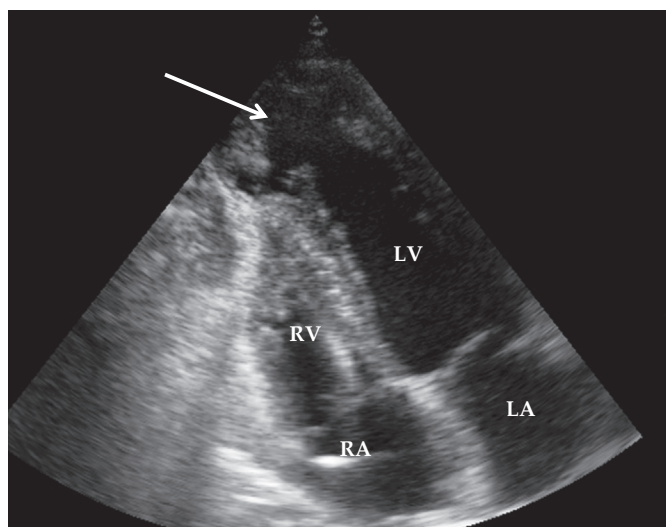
Echocardiography study demonstrating apical aneurysm of the left ventricle (arrow) in a patient with Chagas heart disease. RA, Right atrium; LA, Left atrium; RV, Right ventricle; LV, Left ventricle. Adapted from the personal collection of João Marcos Barbosa-Ferreira, University of the State of Amazonas, Manaus, AM, Brazil.
